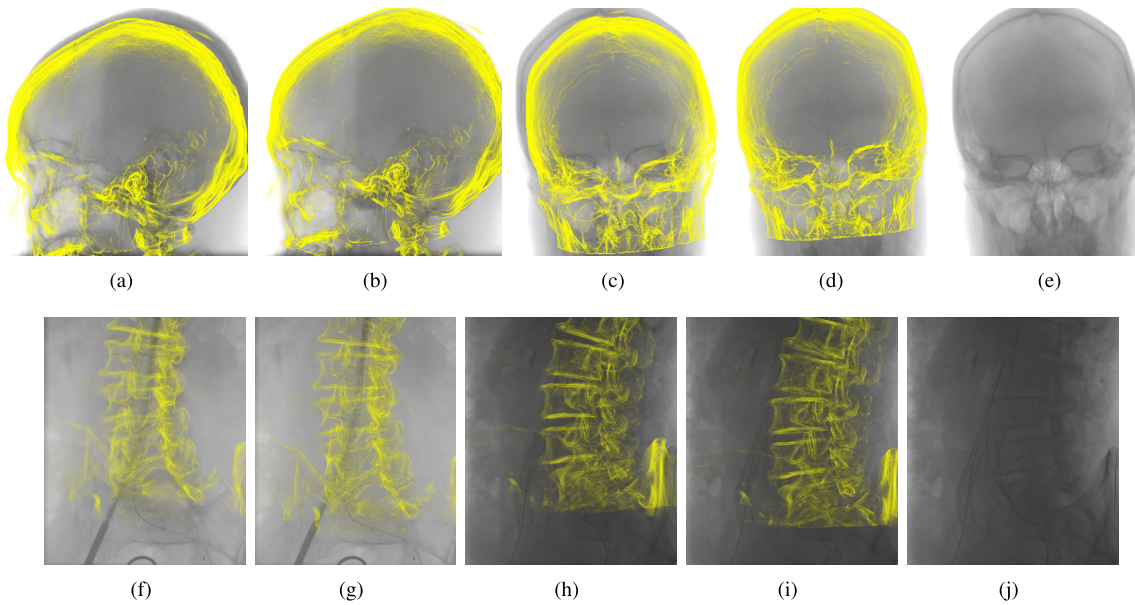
Clinical evaluation on a cerebral aneurysm case (a-e) and an abdominal aortic aneurysm case (f-j). Registrations are based on single-view X-ray images (a,b) and (f,g). Quasi-perpendicular views (c,d,e) and (h,i,j) show the registration accuracy.
